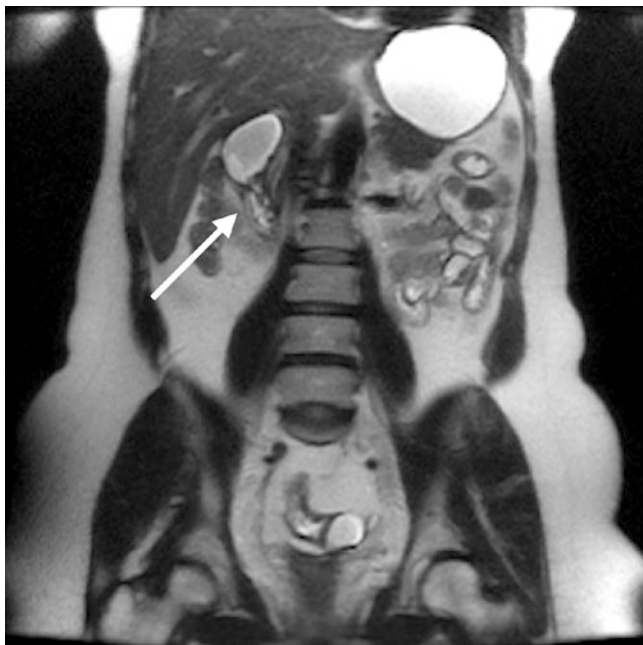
T2-weighted MRI demonstrating a duodenal stricture (arrow). (Courtesy of A. Oto, MD)
